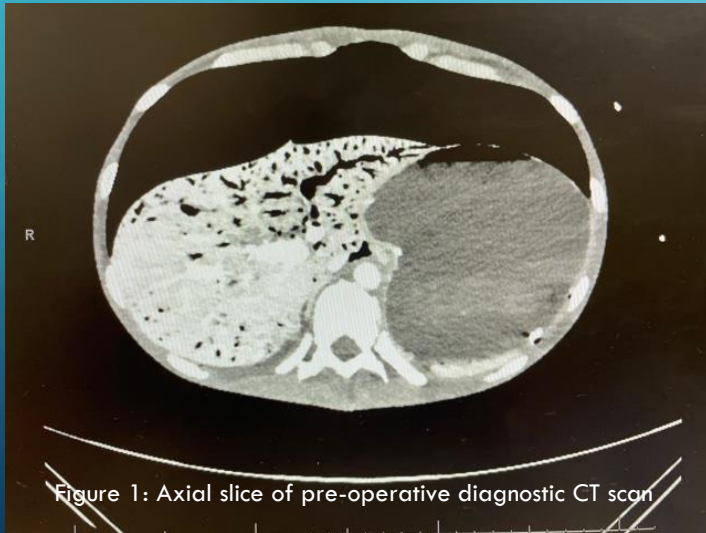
Axial slice of pre-operative diagnostic CT scan
